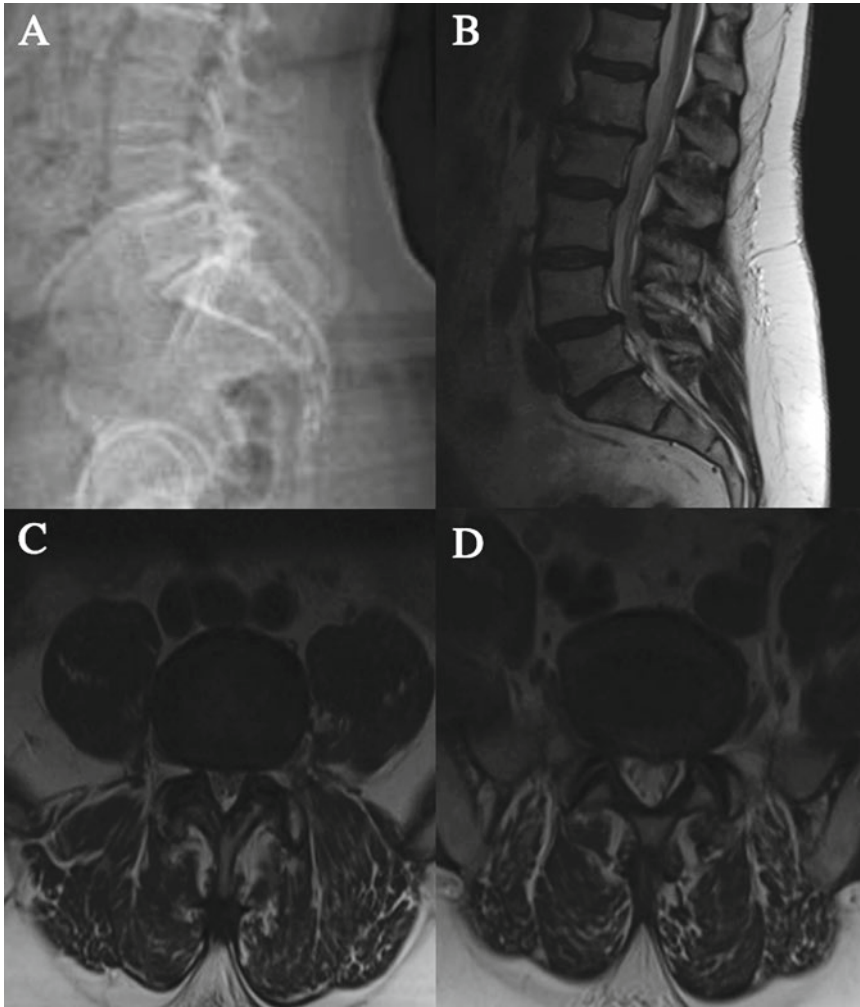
Case example preoperative imaging. A lateral radiograph (a) and sagittal (b) and axial MR of the L4–L5 (c) and L5–S1 (d) disc space demonstrate an L4–L5
